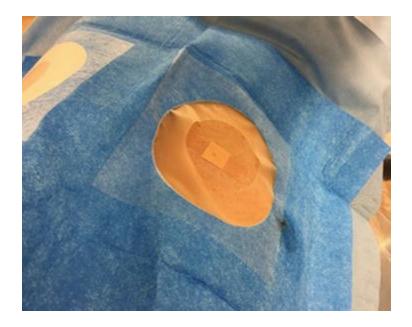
"Band-Aid surgery" - appearance after CT-RFA renal tumor ablation
